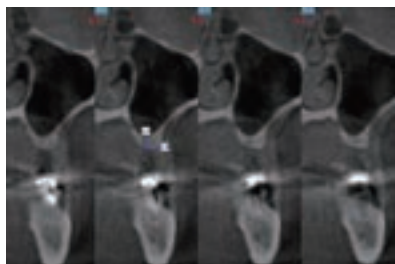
Case 1 cross sectional CT images.
